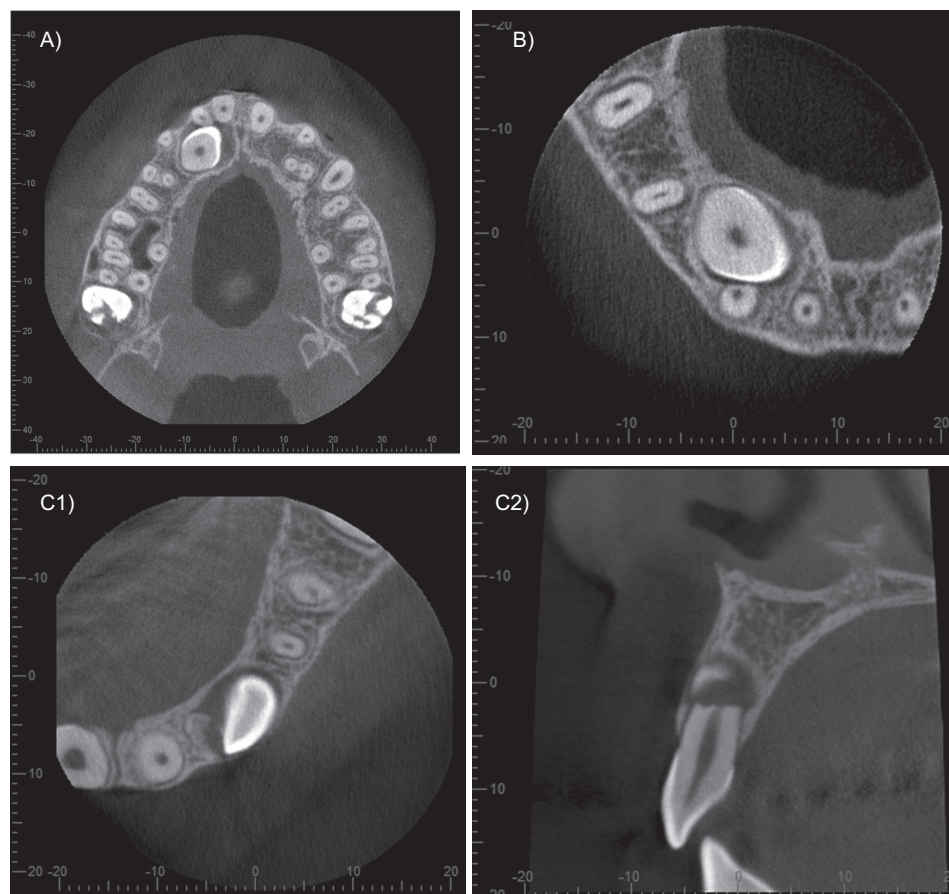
Representative example of different types root resorption: (A) slight root resorption on a right lateral incisor; (B) moderate root resorption on a right lateral incisor; (C1) severe root resorption on a left lateral incisor (axial CBCT scan); (C2) Same patient as in C1 (sagittal CBCT scan).
